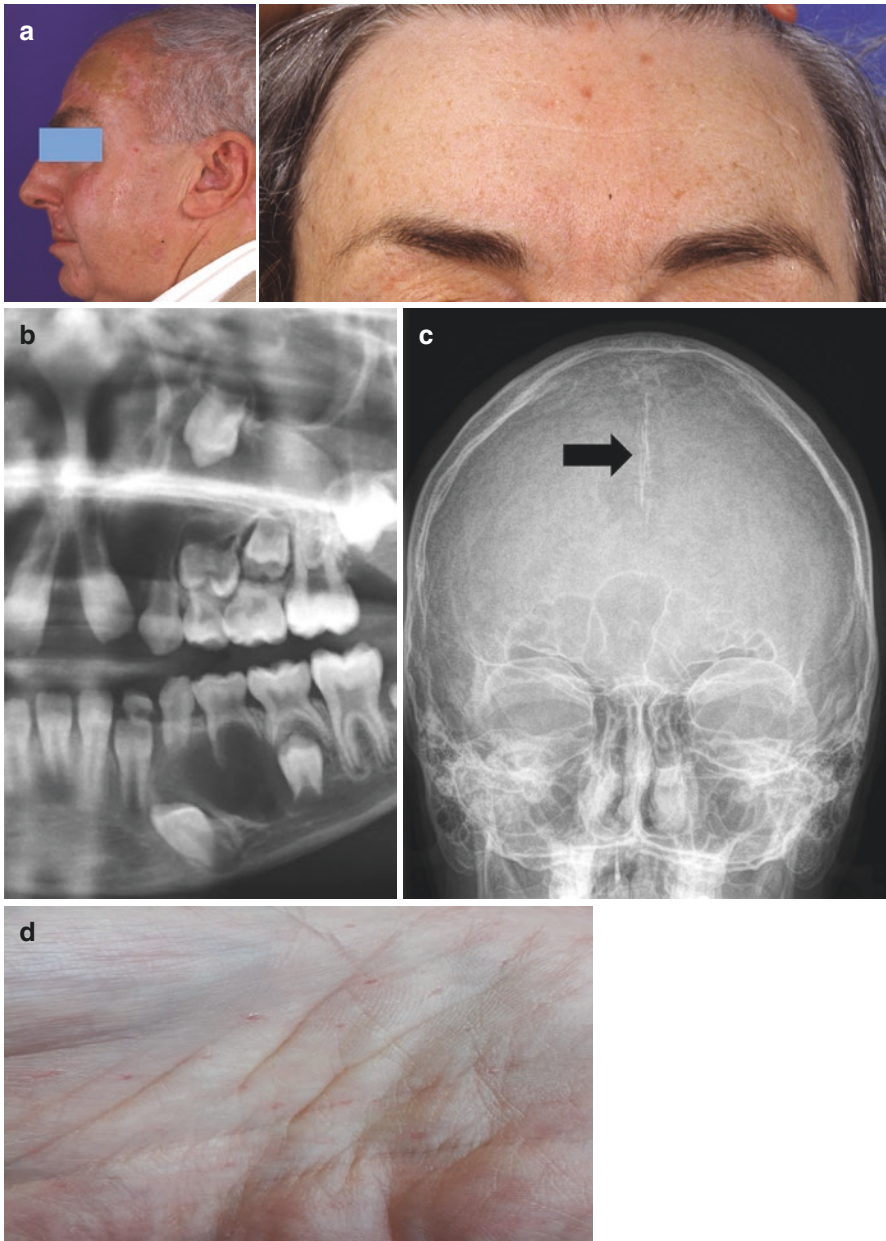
(a) Left: Profile of a patient with GGS. Multiple scars and skin transplant resulting from uncounted surgical procedures for BCC excision. Note two scabbing ulcerations of pinna. Right: Frontal bossing and multiple nevi in a patient with GGS. (b) Orthopantomography of jaws of a young patient with GGS (cropped image, left body side). Note multiple cystic lesions in both jaws and retained permanent teeth. All cystic lesions proved to be odontogenic keratocysts (OKC). While the X-ray findings of solitary keratocysts are ambiguous, syndromic lesions mostly present as multiple OKC. (c) Posterior-anterior skull radiograph of a child with GGS. Note bilamellar ossification of falx cerebri (arrow). (d) Palmar pits in a GGS patient
